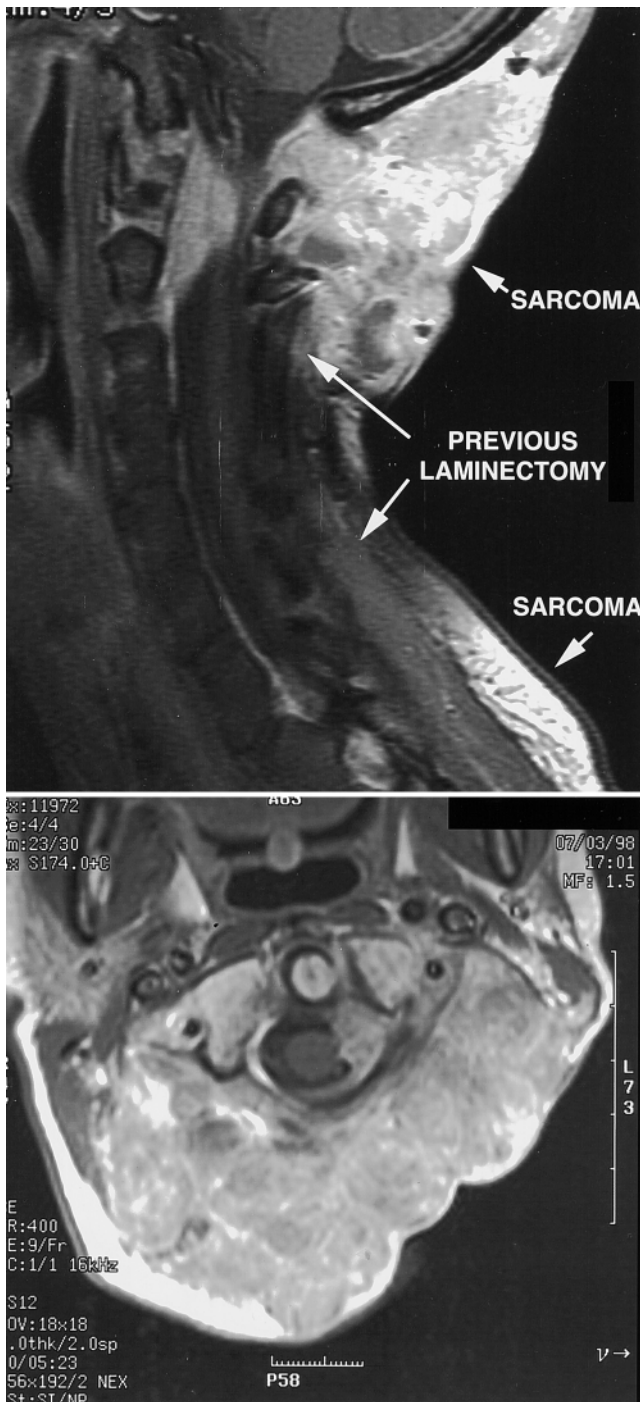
Case 12. Preoperative contrast-enhanced sagittal (upper) and axial (lower) MR images demonstrating recurrent posterior occipitocervical sarcoma.
